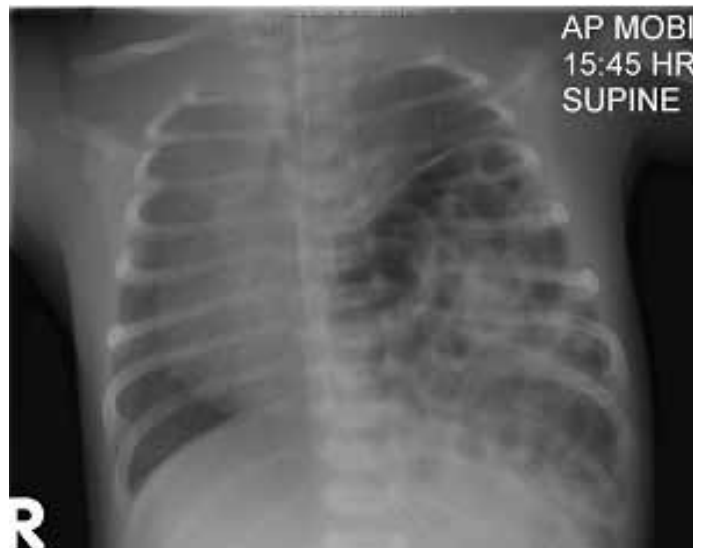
Chest x-ray showing a left CDH. Bowel loops are seen in the chest, and there is mediastinal shift. The appearances could be similar to congenital lung cysts, and an abdominal x-ray is needed to confirm the diagnosis.
